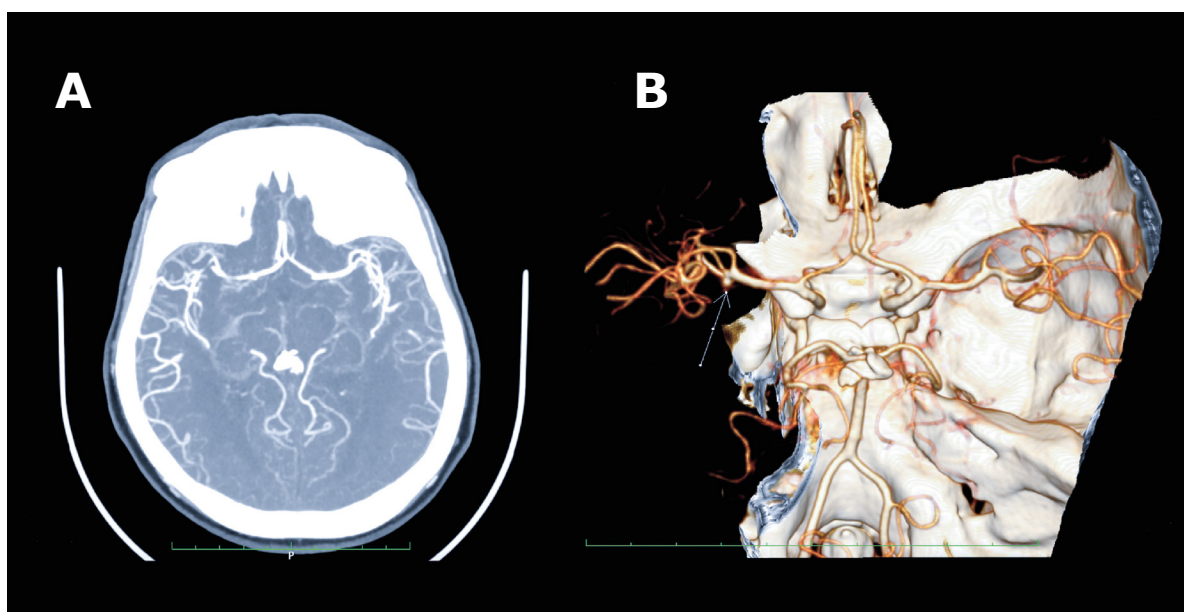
CTA two-dimensional axial projection with a M1 trifurcation with an aneurysm (A), CTA three-dimensional projection of the M1 division – a trifurcation of M1 with aneurysm (B)
